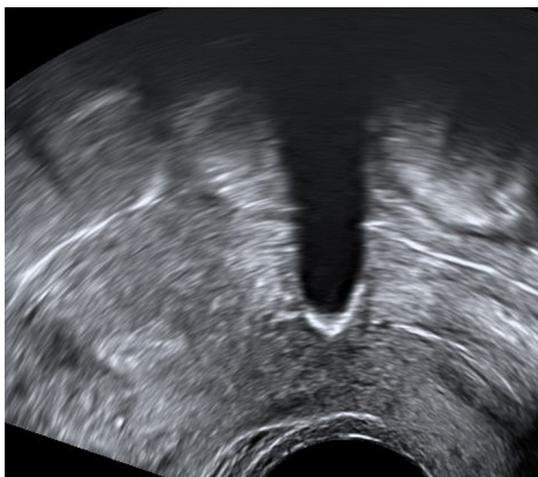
3D ultrasound coronal plane- hyperechoic area with irregular shape in the isthmic region of the uterus.
